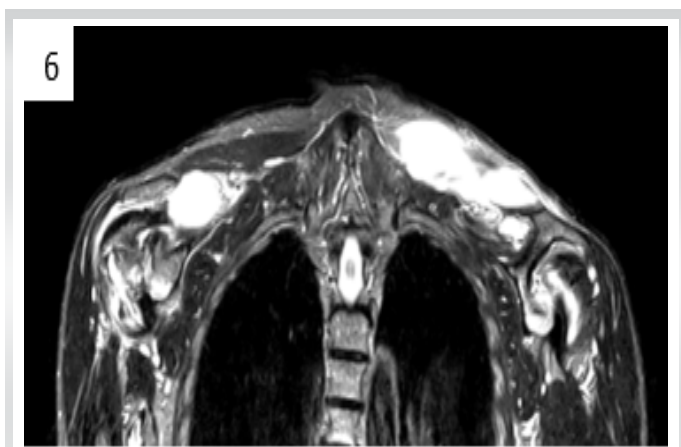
MRI Coronal view.
